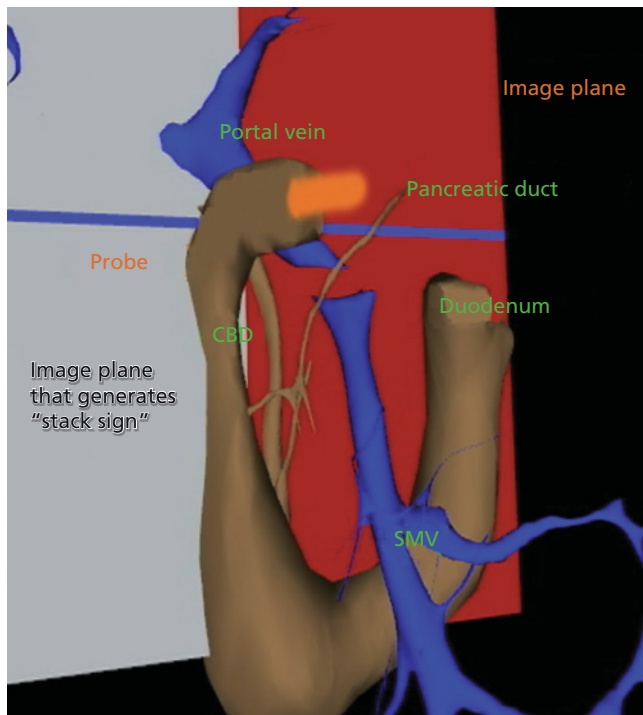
Visible Human Model of an image plane that is in the location in which radial array endoscopic ultrasound (EUS) generates the “stack sign”, in which the portal vein, common bile duct (CBD), and pancreatic duct are in the same field. A probe in orange is shown going into the proximal duodenum. The superior mesenteric vein (SMV) is also shown.
